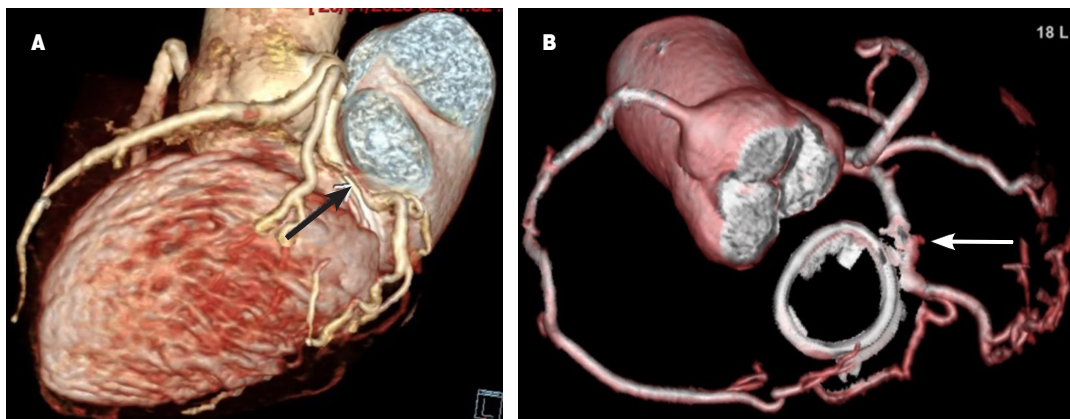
Coronary computed tomography angiography three-dimensional reconstruction. A) Stenosis at the middle third of the Circumflex Artery (CxA) with close relation to the annuloplasty ring (white arrow shows the annuloplasty ring). B) Three-dimensional reconstruction of the CxA and the annuloplasty ring that shows how the annuloplasty ring compresses the CxA with a significant stenosis (white arrow).
